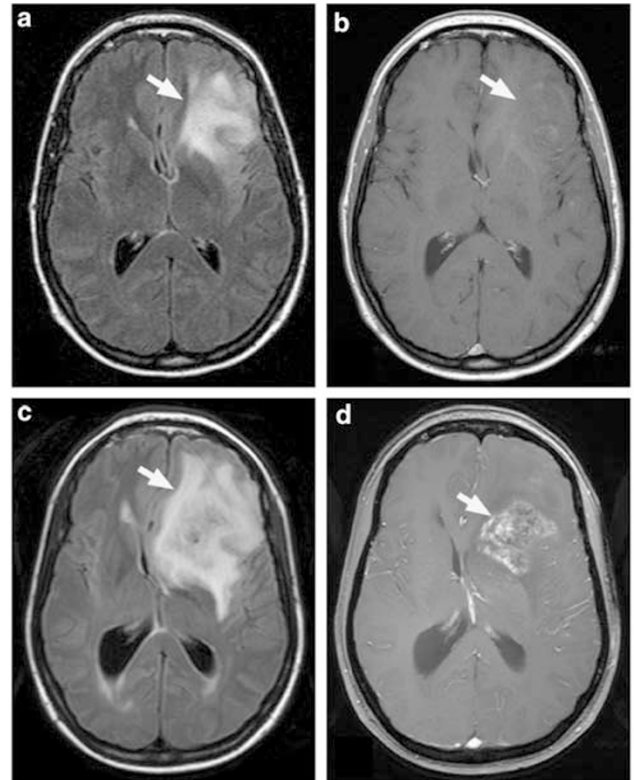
AA (WHO grade III) and GBM (WHO grade IV) have distinct growth patterns by MRI. (a) A 47-year-old woman with seizures was found on MRI to have a left frontal lobe lesion, which on biopsy proved to be an AA. Axial MR images shows increased signal intensity on FLAIR imaging, representing vasogenic edema in response to infiltrating tumor cells (arrow). (b) Following the administration of contrast agents, most AAs do not show enhancement on T1-weighted images due to an intact blood–brain barrier and a lack of central necrosis (arrow). (c) After 1 year, the same patient developed worsening symptoms and was rescanned, revealing progression to GBM. GBMs also have hyperintense regions at their periphery on FLAIR imaging, indicative of diffusely infiltrating tumor cells (arrow). (d) A distinguishing feature is the emergence of a contrast-enhancing component centrally, which rapidly expands radially (arrow). Note the degree of midline shift in the GBM that was not present in the AA.
